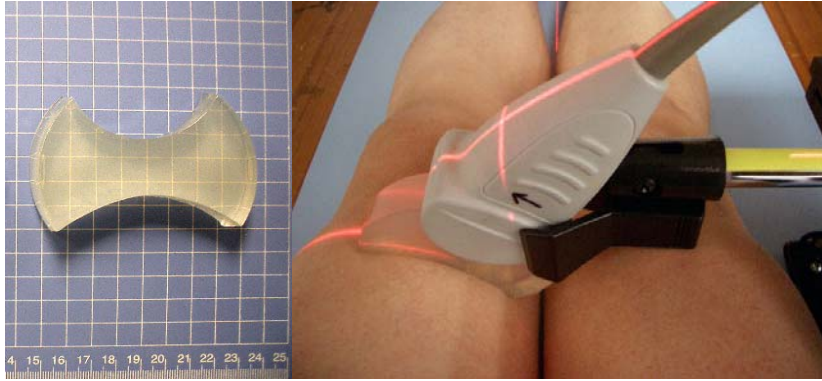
Ultrasonic scanning for VMO. The pre-molded ultrasound gel pad (left) acts as a medium between the ultrasound probe and the skin underneath (right).
